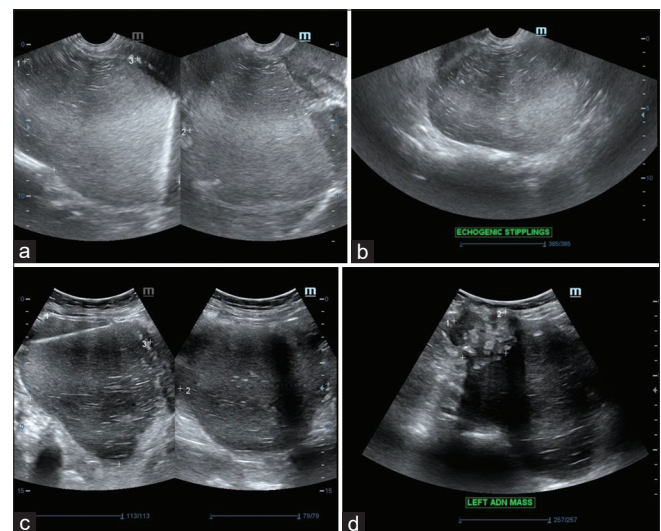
(a) Transvaginal ultrasound. Large unilocular cystic mass in the pelvic cavity with smooth outline measuring 11.7 cm × 10.6 cm × 9.0 cm. An incomplete septum is noted in its anterior aspect. No color flow noted in color Doppler scan. There is also hyperechoic mass left to the cystic mass with lobulated border measuring 4.8 cm × 4.6 cm × 3.37 cm which maybe colonic in origin. (b) Transvaginal ultrasound. Echogenic stipplings were noted. (c) Transvaginal ultrasound. Heterogenous cystic mass is 12 cm × 11 cm × 10 cm with echogenic stippling. (d) Transvaginal ultrasound. Echogenic core measuring 4.1 cm × 4.2 cm
